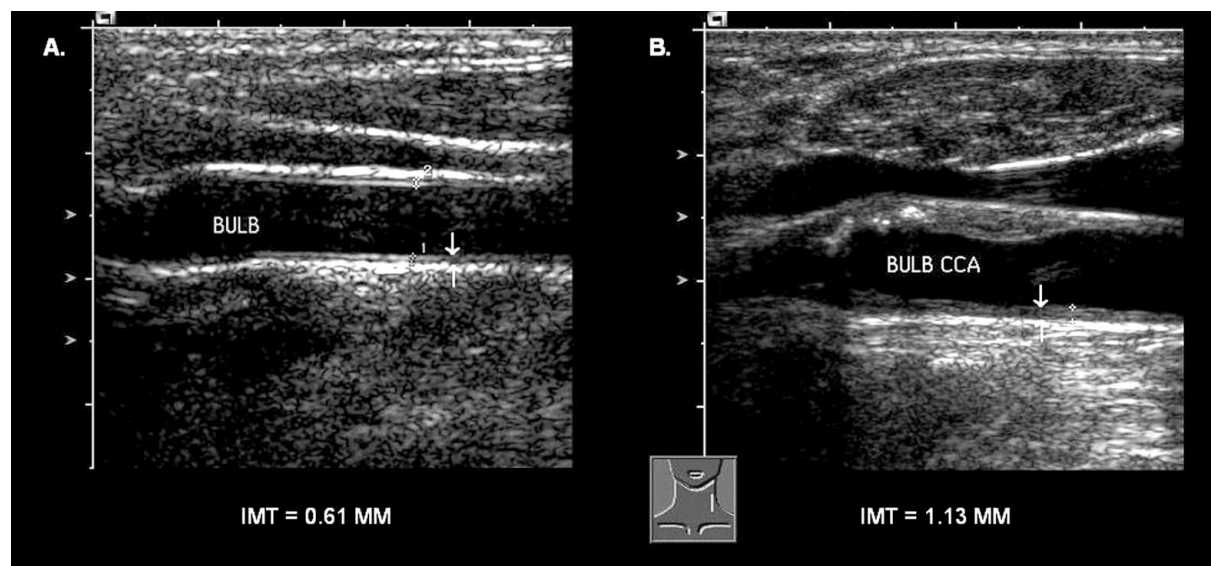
Measurements of the intima-media thickness (IMT) of the common carotid artery (CCA) using ultrasonography (arrows). A. MI patient with IM thickening. B. Healthy subject with normal IMT.
